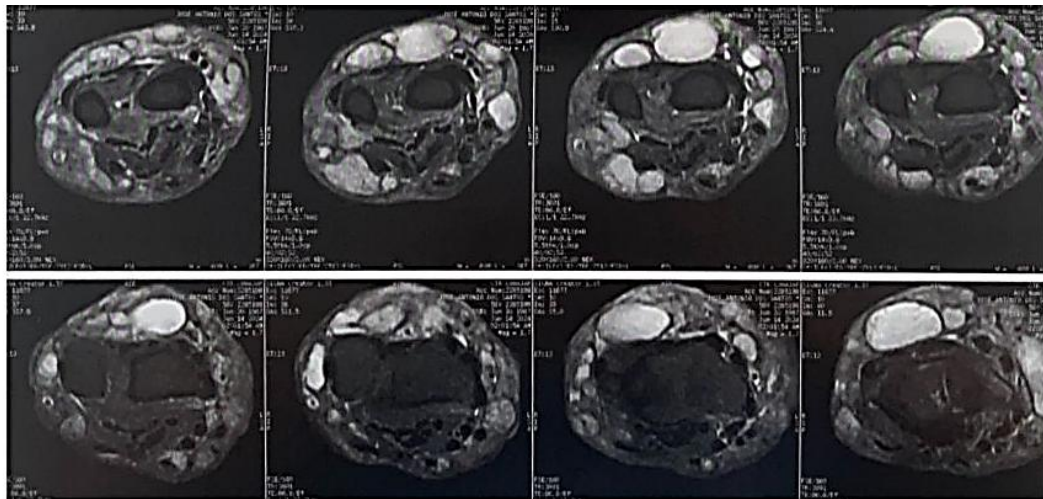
MRI showing multicompartiment subcutaneous and intermuscular nodular lesions with features suggestive of necrotic or liquefied content.
